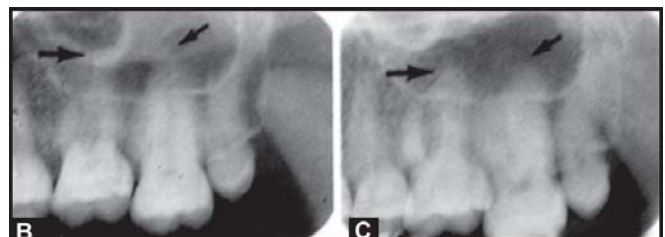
Radiographs made with B. Bisecting angle technique C. Paralleling technique
